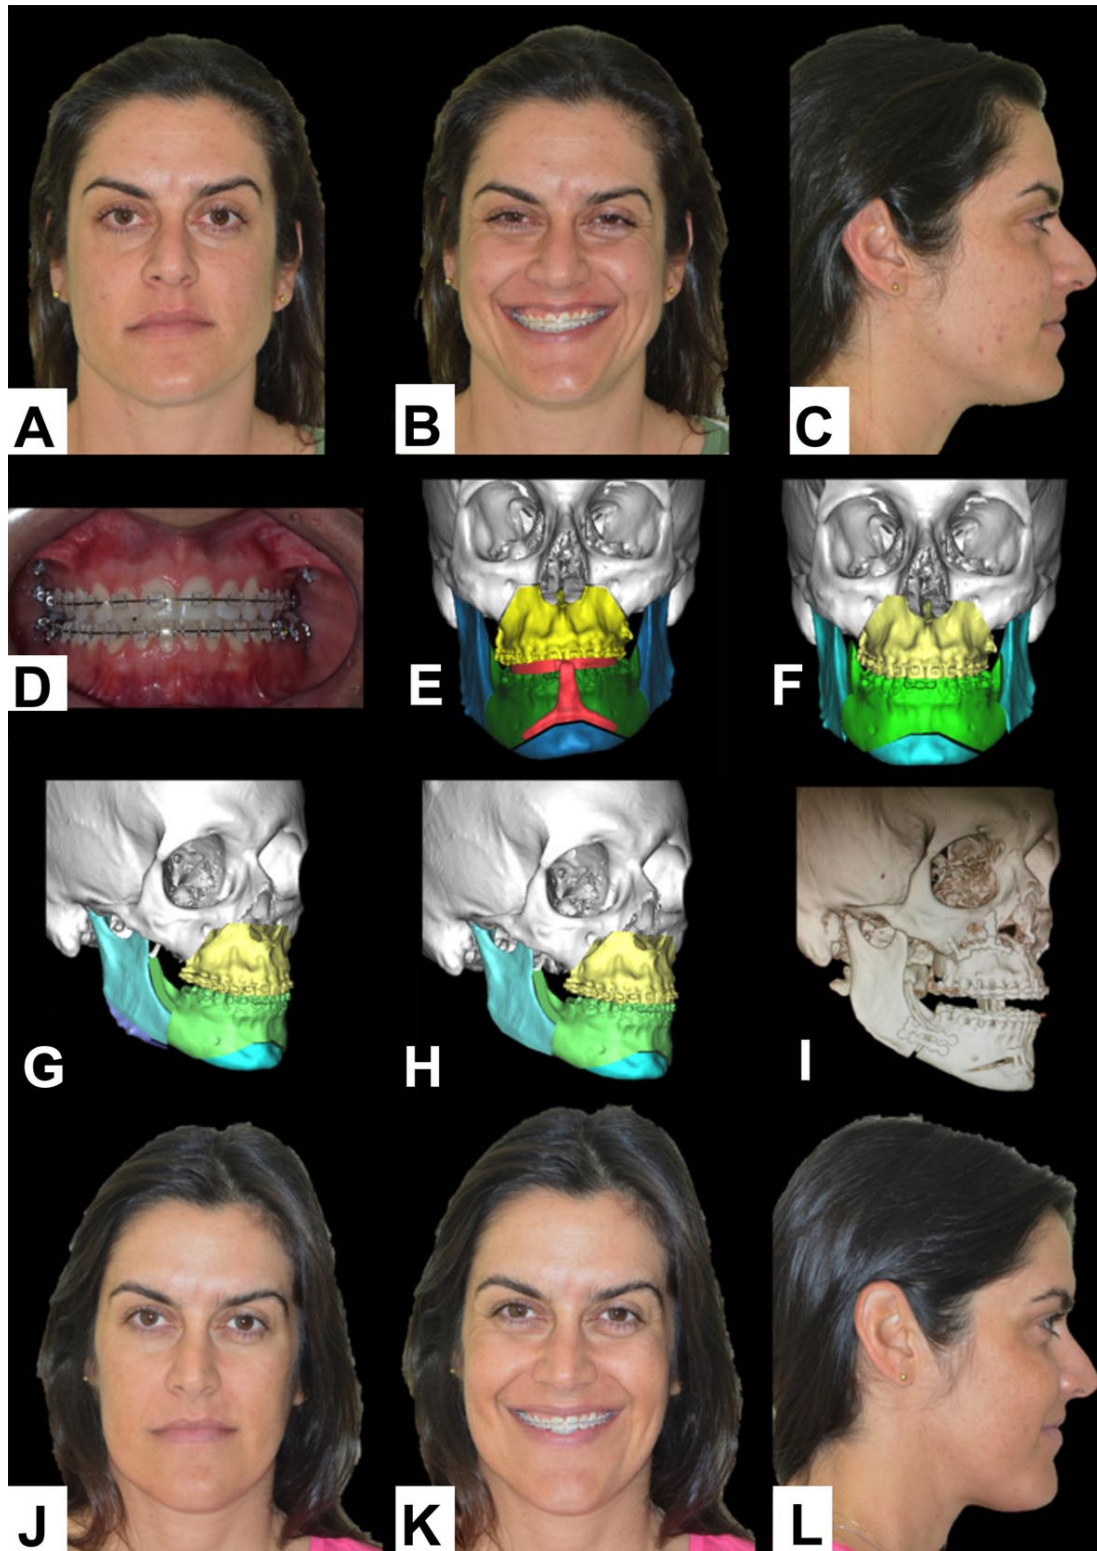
A- Laterognathism with mandibular deviation to the left side; B- Smile asymmetry, and maxillary cant; C- Lateral view show maxillary deficiency; D- Occlusal compensation; E- Compound skull and guide to genioplasty cut; F- VSP, note the bone excess in mandibular bilateral rami; G- Osteoplasty demarcation; H- Mandibular osteoplasty; I- Post operative CT; J and K- Facial harmony; L- Good profile.
